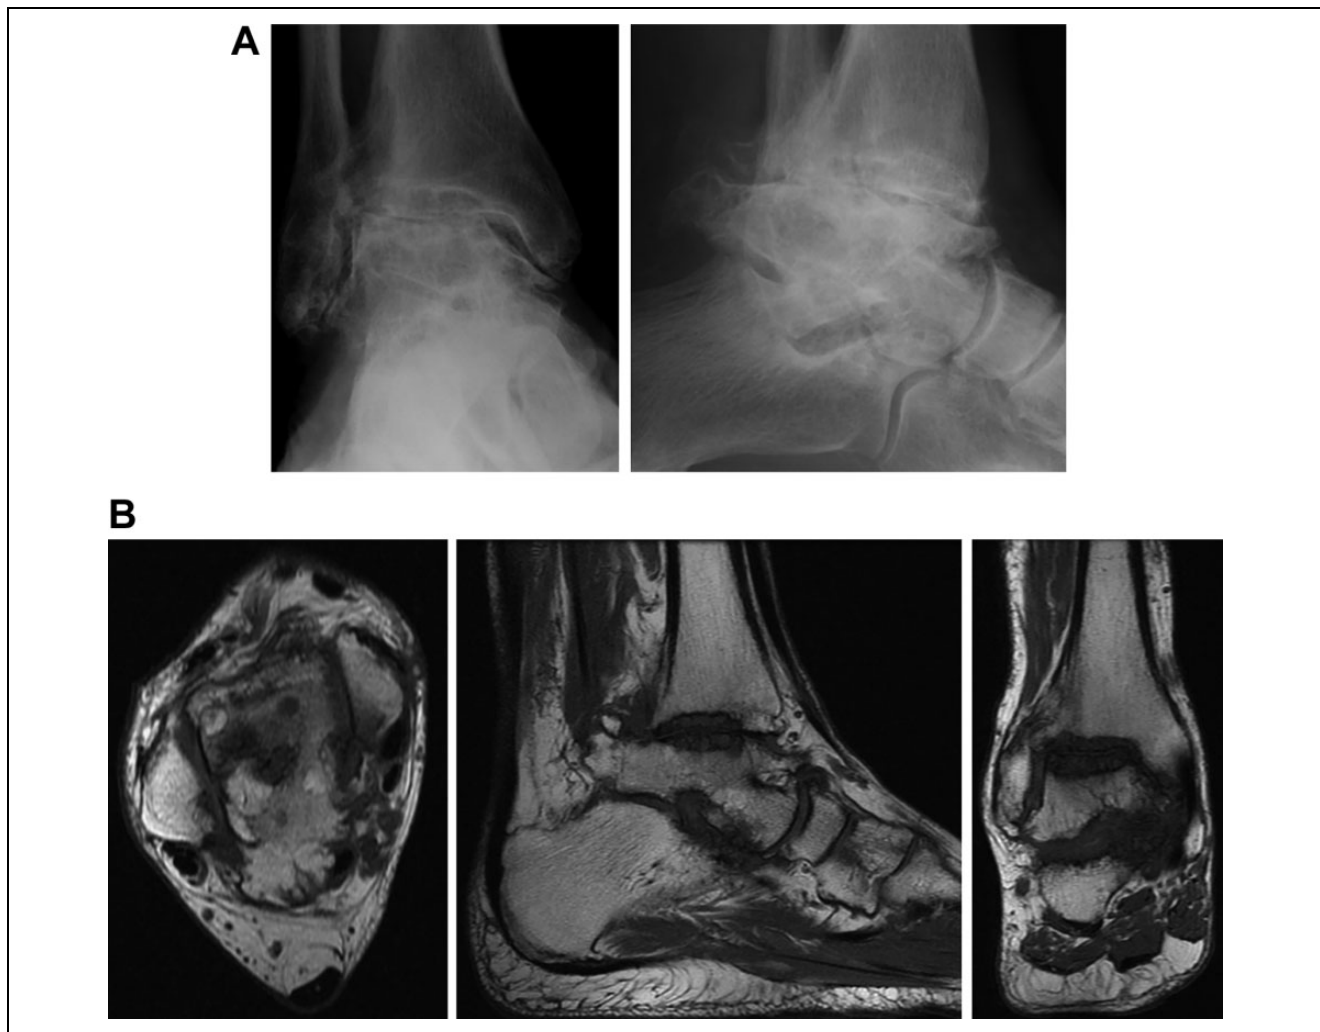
(A) Preoperative anteroposterior and lateral weightbearing radiographs of a 76-year-old man with a remote history of right ankle trauma without prior surgical intervention. There is severe ankle arthropathy with flattening of the talar dome suggestive of avascular necrosis. (B) Axial, sagittal, and coronal T1-weighted 1.5-tesla magnetic resonance images of the same patient demonstrating severe osteoarthritis of the tibiotalar and subtalar joints with loss of articular cartilage and marked cystic changes in the periarticular subchondral bone of the tibia and talus.
